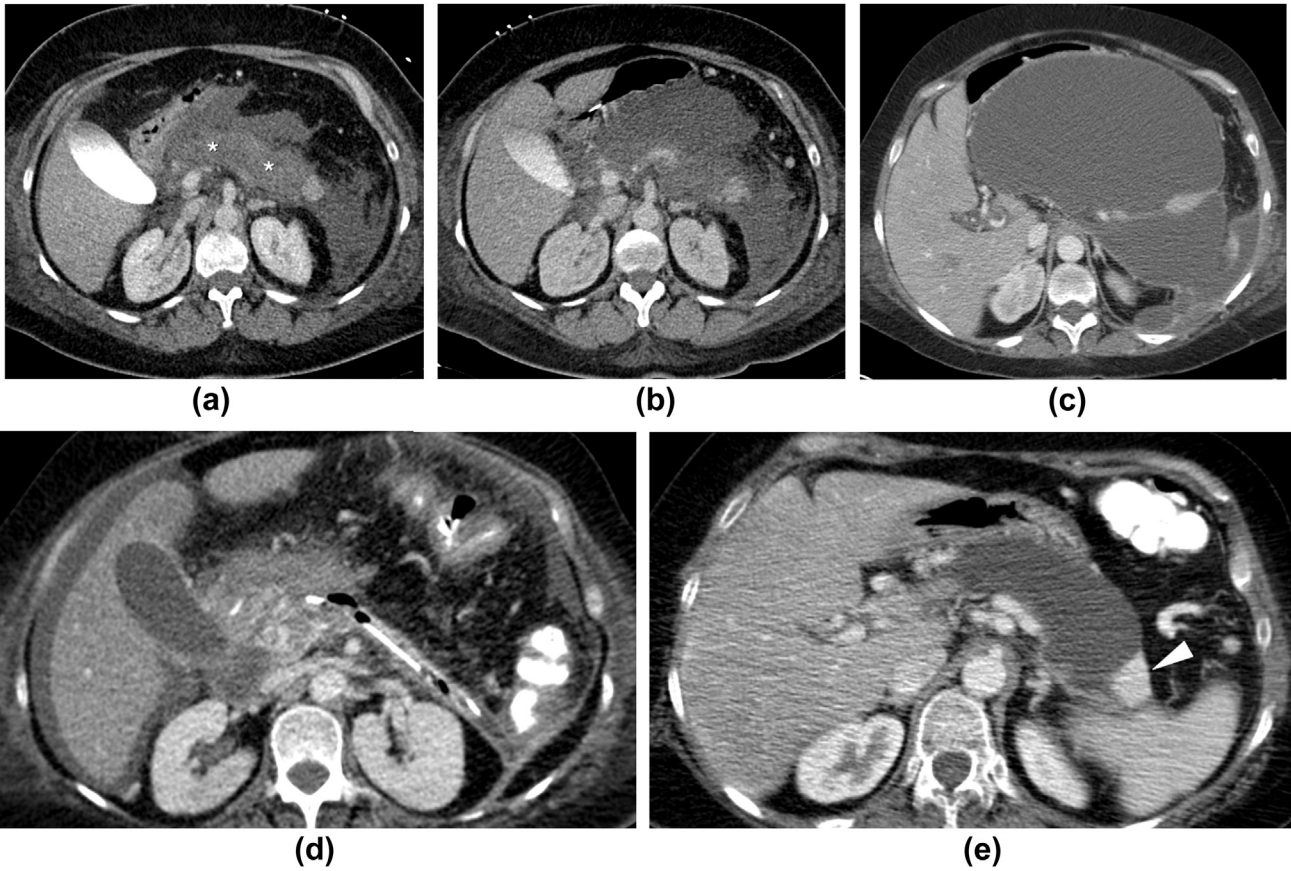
Post-necrosectomy pseudocyst developing in a 42-year-old woman with necrotising pancreatitis of the central gland after surgical retroperitoneal debridement. (a) Five days after symptom onset, contrast-enhanced CT depicts necrosis of the pancreatic neck, body, and part of the tail (asterisks) with sparing of the distal tail. Note the presence of ANCs adjacent to the pancreas. Serial CT images at day 13 (b) and day 35 (c) show enlarging collections. The patient underwent surgical debridement via the left retroperitoneum (d) with resolution of collections. (e) One year after debridement, follow-up CT reveals a recurrent homogeneous encapsulated collection in the pancreatic area consistent with a post-necrosectomy pseudocyst. Arrowhead points to the viable remnant tail.
